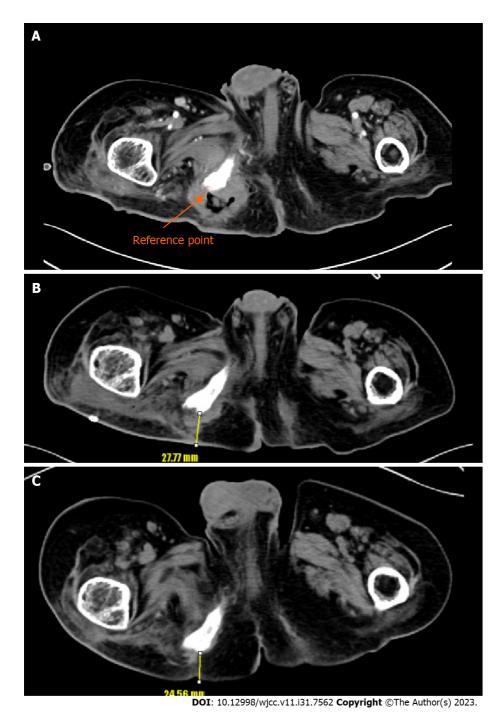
Computed tomography findings. A: Preoperative computed tomography (CT) findings: Reference point (orange arrow); B: Postoperative CT findings after 3 wk from reconstruction: Distance between reference point and skin is measured 27.77 mm (yellow arrow); C: Postoperative CT findings after 6 mo from reconstruction: Distance between reference point and skin is measured 24.56 mm (yellow arrow).
